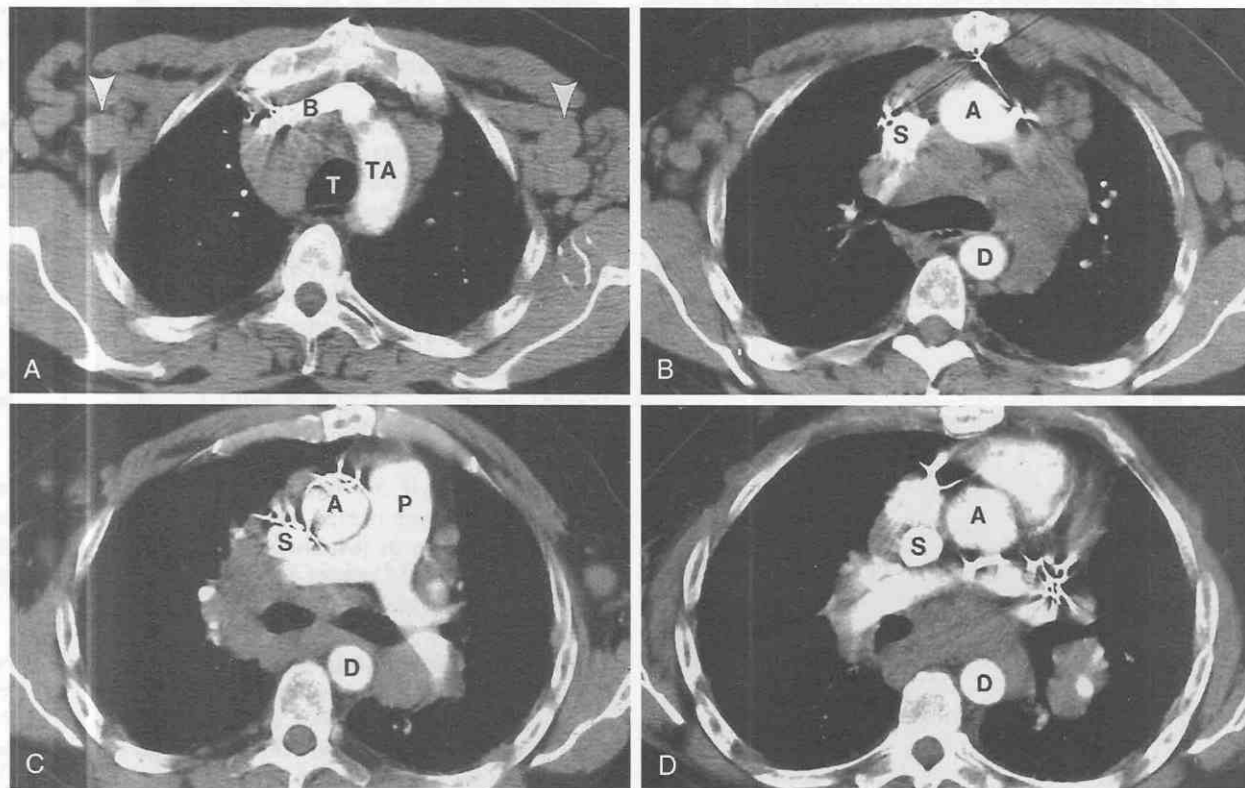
Diffuse mediastinal adenopathy in a patient with chronic lymphocytic leukemia. Contrast-enhanced CT shows marked intrathoracic adenopathy in the paratracheal and prevascular mediastinum (A), precarinal region and aortopulmonary window (B), left and right hilum (C), and subcarinal region (D). Axillary adenopathy can be seen (arrowheads in A). A, ascending aorta; B, brachiocephalic vein; D, descending aorta; P, main pulmonary artery; S, superior vena cava; T, trachea; TA, transverse aorta.
